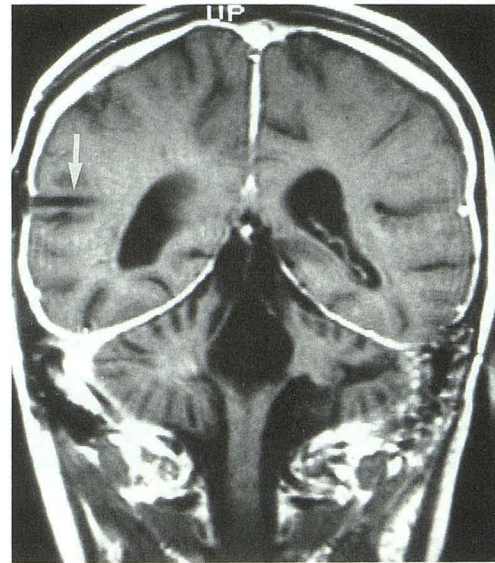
MR image of a 12-year-old girl obtained 9 months after surgery. Enhanced short-TR (760/20) coronal MR image shows prominent diffuse dural enhancement. A shunt tube tract is also seen (*arrow*).
